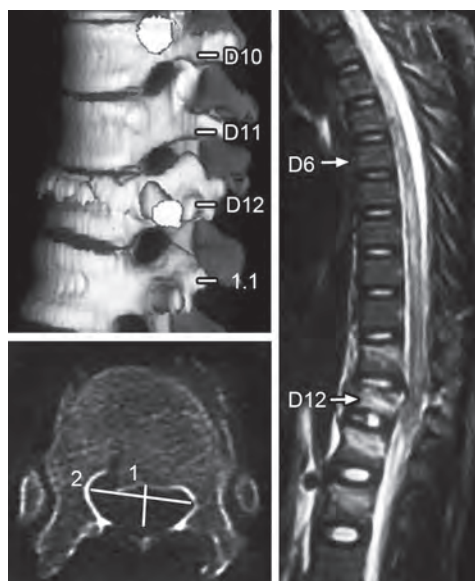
Ascending cord oedema (right-sagittal T2-weighted MR) up to cervical region 5 days after stable burst fracture of T12 (left-CT). The patient presented with paraplegia that had ascended from L1 level to T6 level at presentation on the 3rd day, following postural reduction at another hospital. Over the next 2 days he had sensorimotor symptoms and signs up to C8 level. He was treated conservatively and the neurological level descended to T3 in a week
